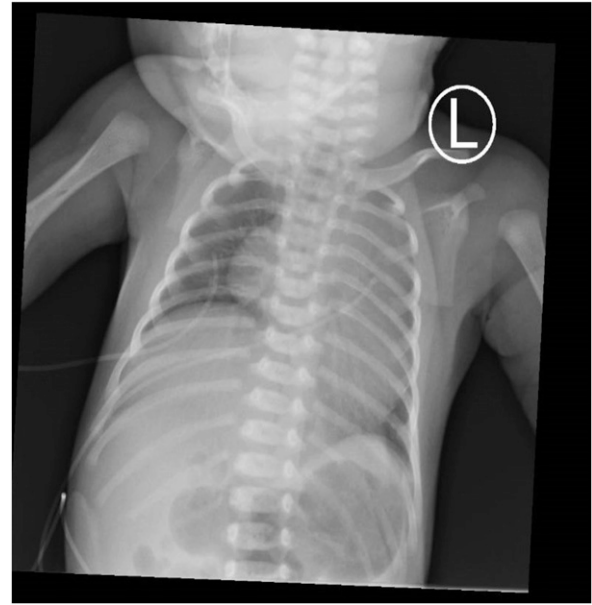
Chest radiograph showing right hemi-diaphragm paralysis.
